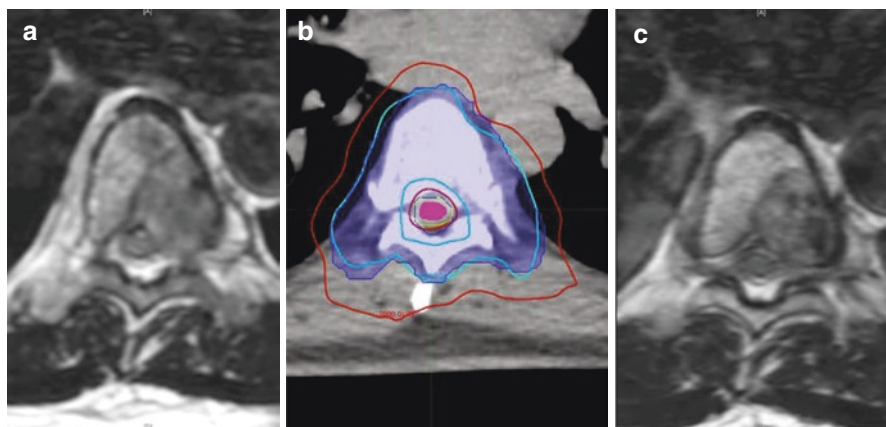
A 61-year-old gentleman with metastatic thyroid cancer to T7 with Bilsky grade 2 metastatic spinal cord compression (left panel); he received SBRT delivering 27 Gy in 3 fractions (cyan) with PRV cord limited to 20.3 Gy (based on Sahgal et al. data) (middle panel); MRI after 3 months showed regression of epidural disease (Bilsky grade 1a disease)
